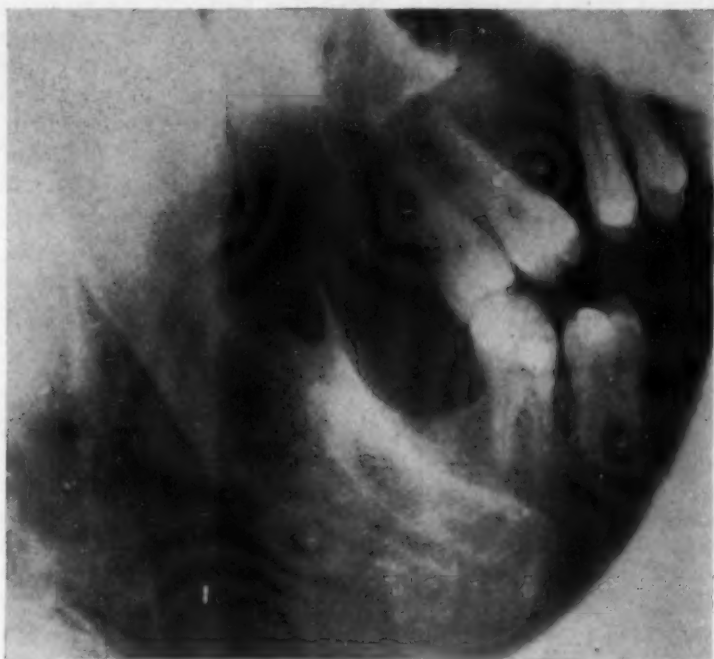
Lateral x-ray view showing elongation of the ramus with an osteolytic defect in the anterior border.
